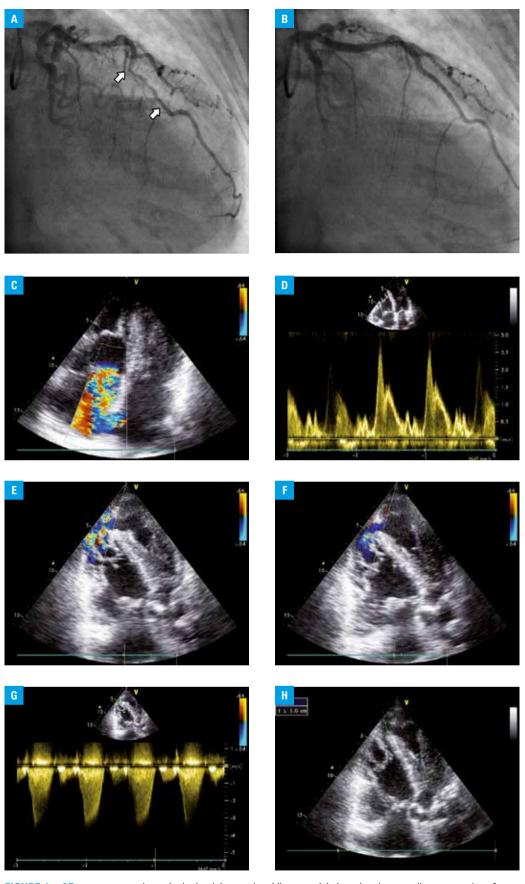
AB – coronary angiography in the right anterior oblique cranial view showing systolic compression of the mid-left anterior descending coronary artery; A – systole, arrows indicate the start and end of the myocardial bridge; B – diastole; CH – transthoracic echocardiography; C – color Doppler imaging of severe tricuspid regurgitation; D – pulsed-wave Doppler imaging of intraventricular obstruction on the level of mid-cavity segments of the left ventricle; EF – transseptal flow on color Doppler imaging (systole and diastole, respectively); G – continuous-wave Doppler imaging of the transseptal flow; H – 2-dimensional image of the rupture
